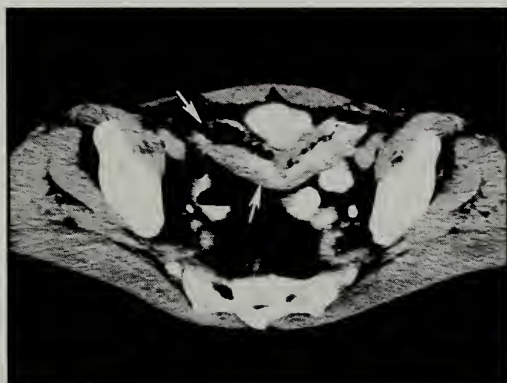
Contrast enhanced axial CT image inferior to Figure 2a.
